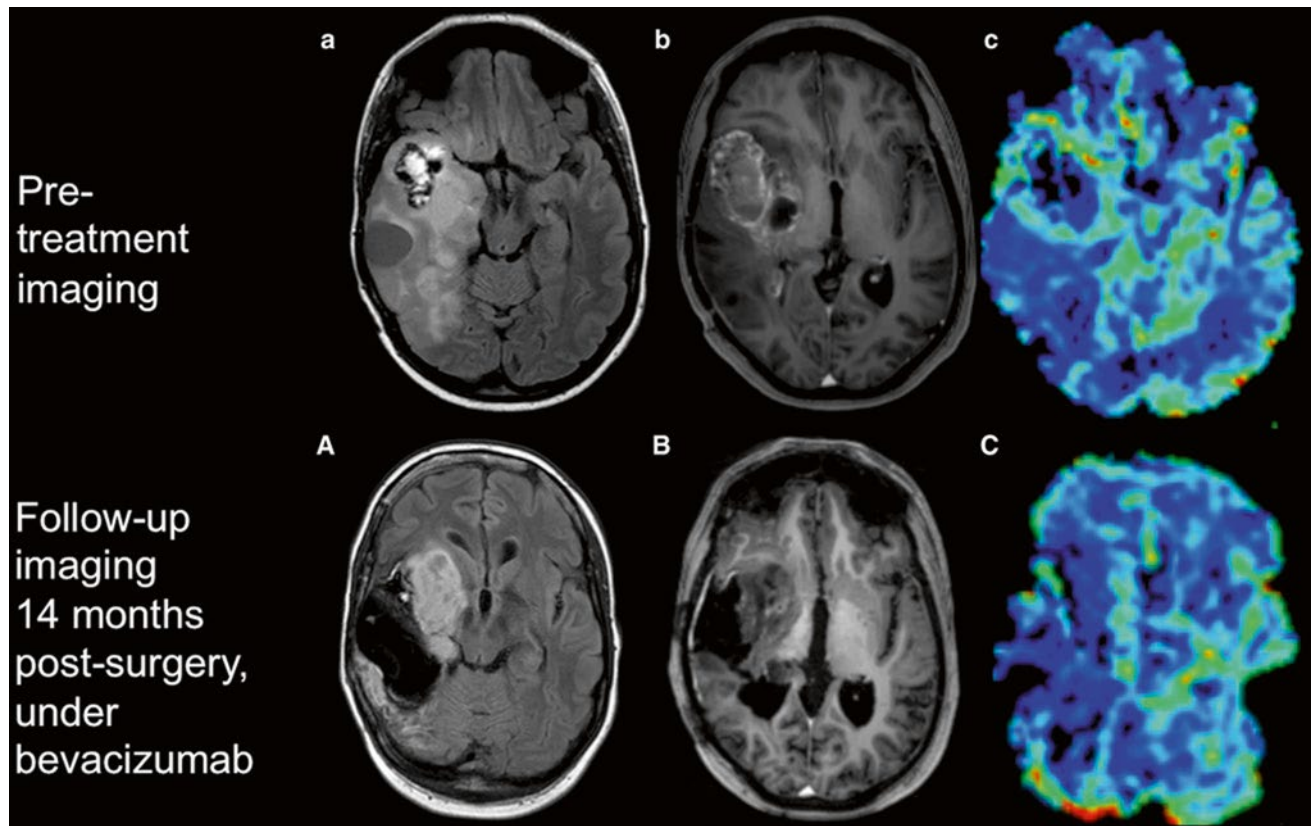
Glioblastoma with anti-angiogenic treatment. (*Upper row*) Pretherapeutic imaging (axial FLAIR, T1w post-Gd, DSC rCBV map). The large, enhancing, partly cystic tumor of the right temporal lobe shows high rCBV values in the solid tumor regions as well as in the infiltration zone (not shown). (*Lower row*) Follow-up of the same
